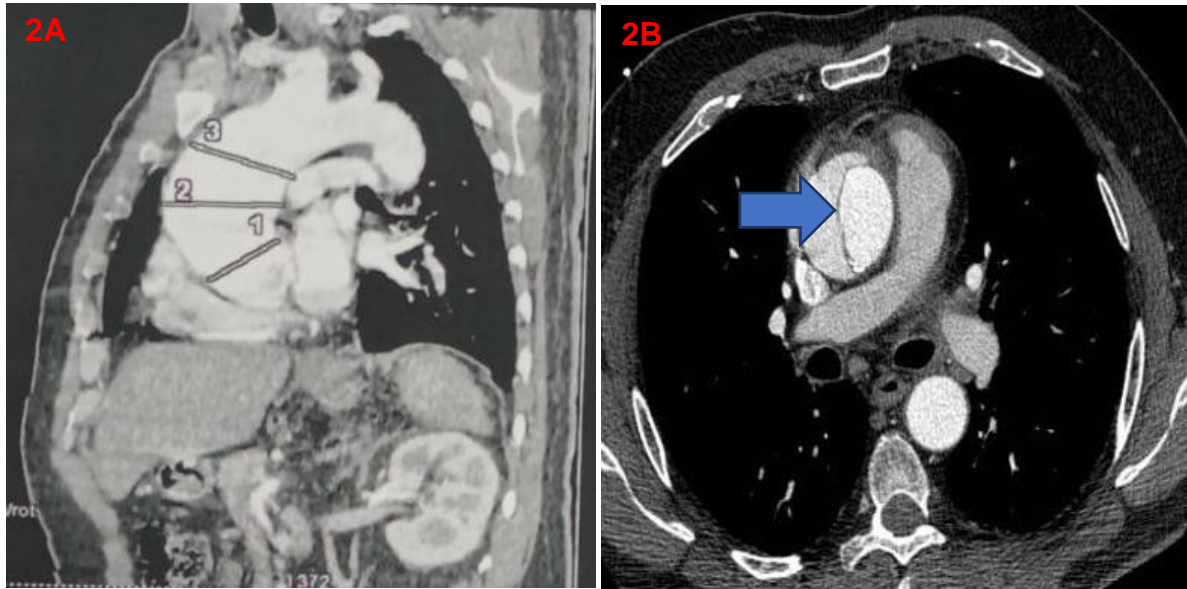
CT angio-scan: showing dilation of the aorta at the aortic valve and sino-tubular junction associated with type A Stanford acute aortic dissection.
